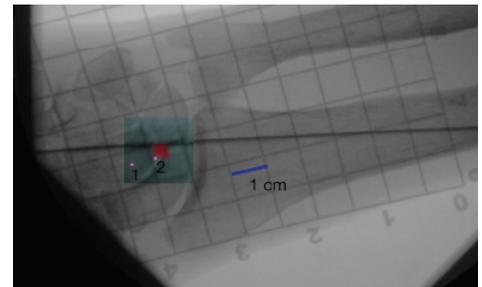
With X-Grid, the target in the hand was localized with 2 fluoroscopic X-rays.
